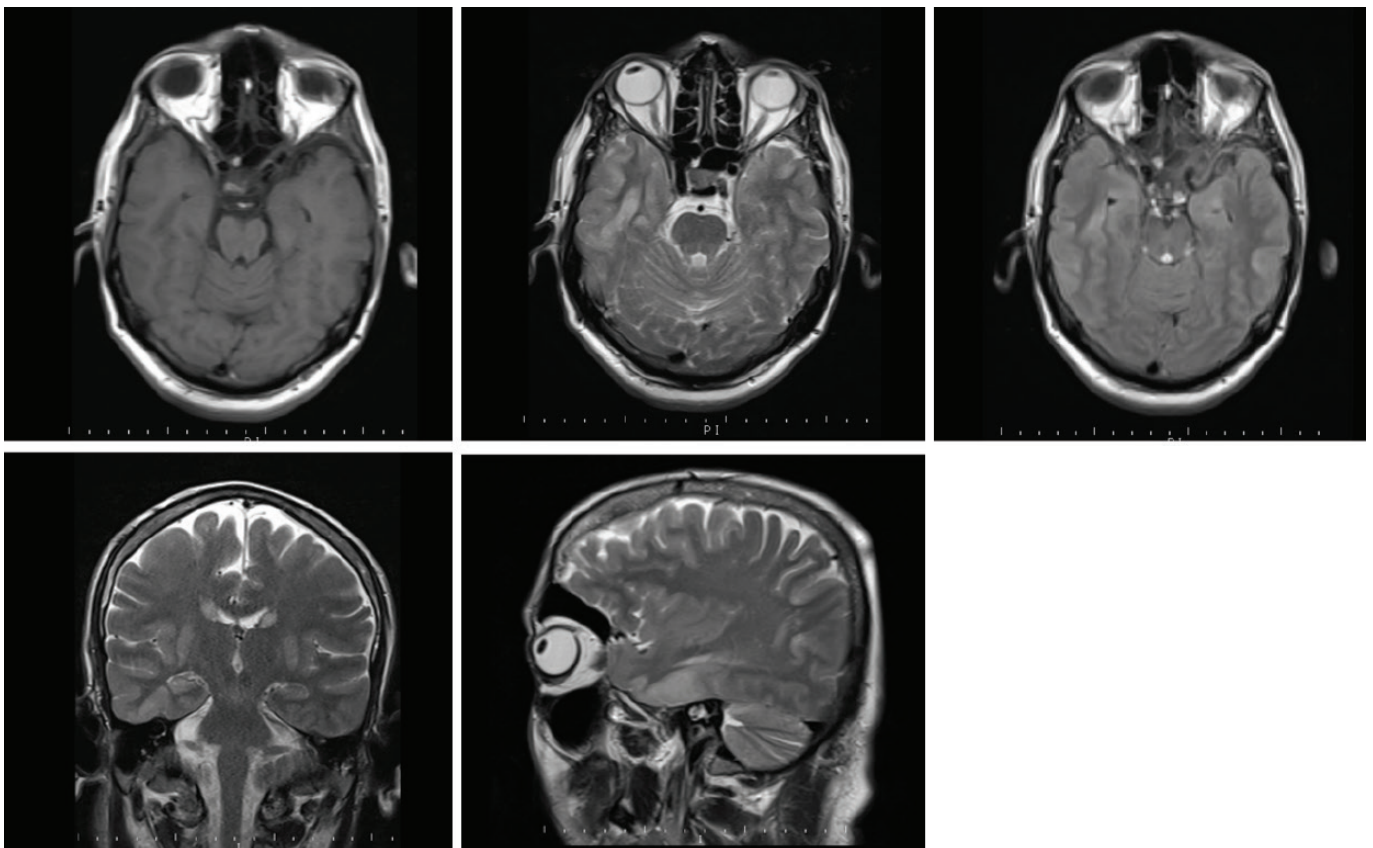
T2W and FLAIR hyperintense, T1W hypointense lesions involving lateral temporal lobes bilaterally suggesting cortical oedema
